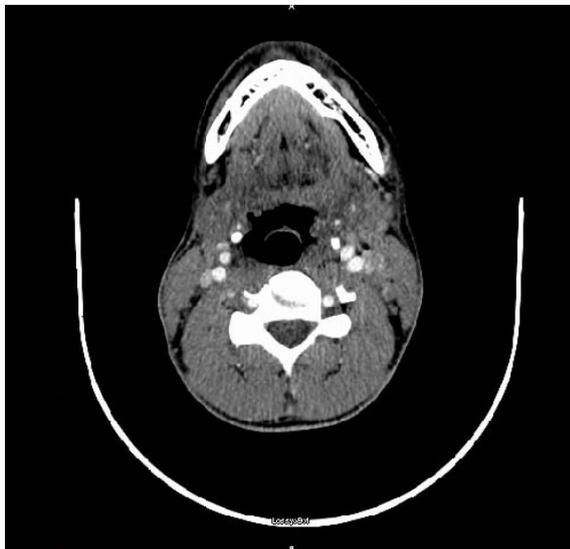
Computed tomography image of the neck: Left-sided peritonsillar phlegmon with associated reactive adenopathy. Note the left internal jugular vein, with an area of limited opacification, concerning for possible thrombosis.
